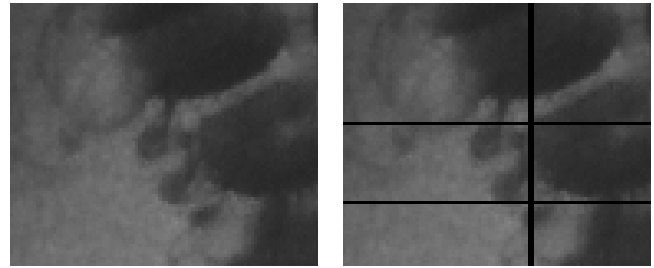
Left: Part of original universal radiography/fluoroscopy sequence 'Colon'. Right: Part of defective sequence 'Colon'.
